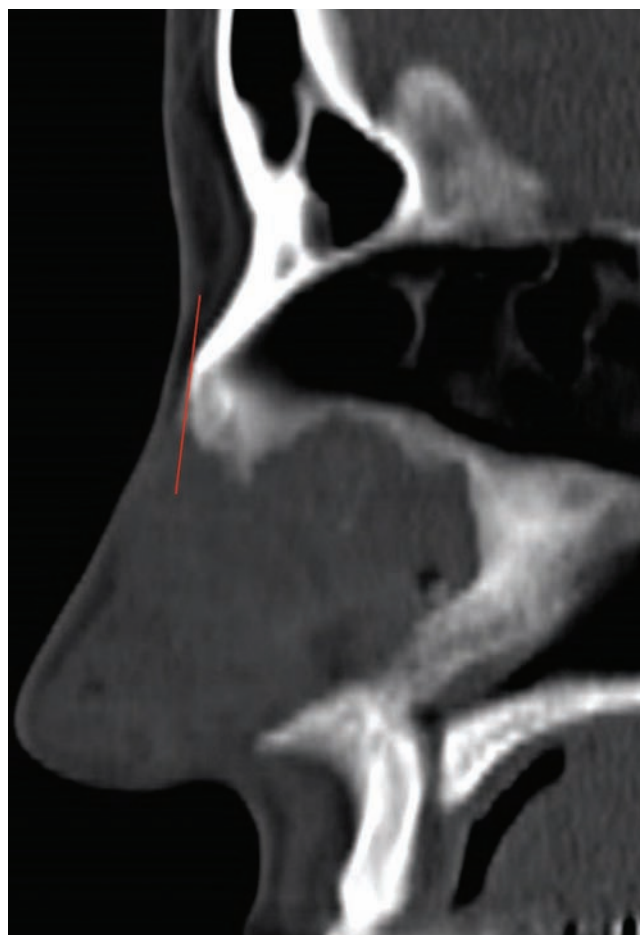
A rare case of E2 classification in which a beveled osteotomy was done (red line). Shown here is the 18-month postoperative computed tomography scan of this 48-year-old male patient.
